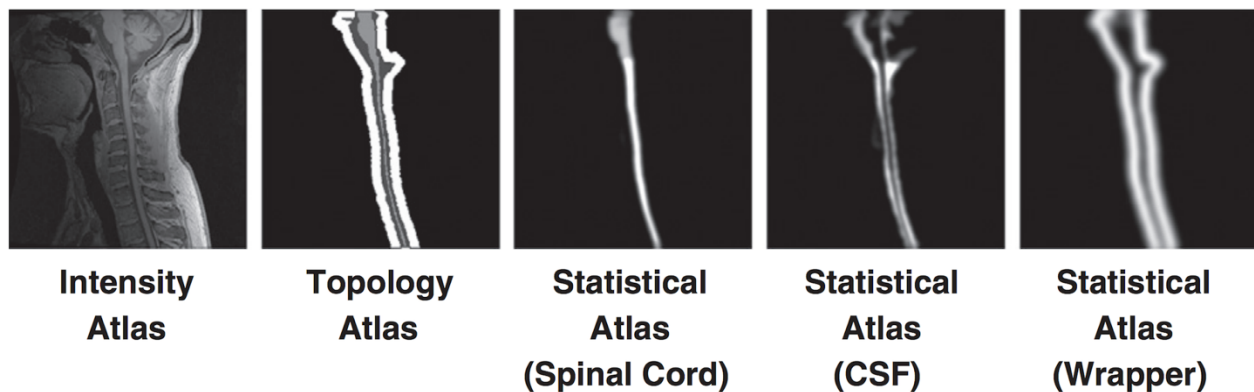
Example of the intensity, topology and statistical atlases constructed from a single T₁-weighted MR image, from Chen *et al.* (2013) (Chen et al., 2013), with permission from Elsevier.
